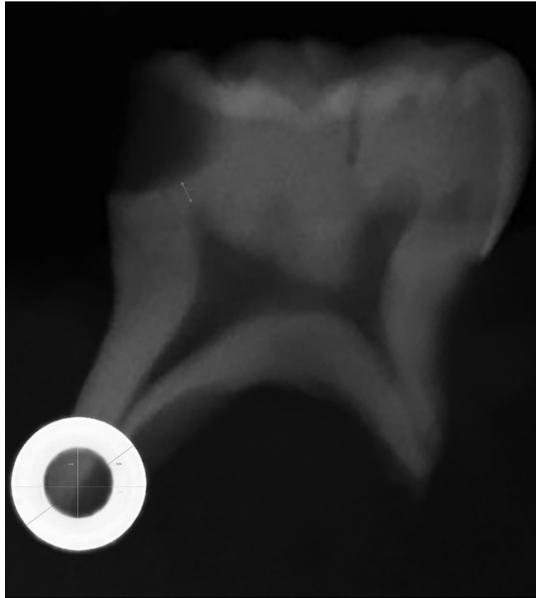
Radiographic measurement of RDT on digital radiograph.
